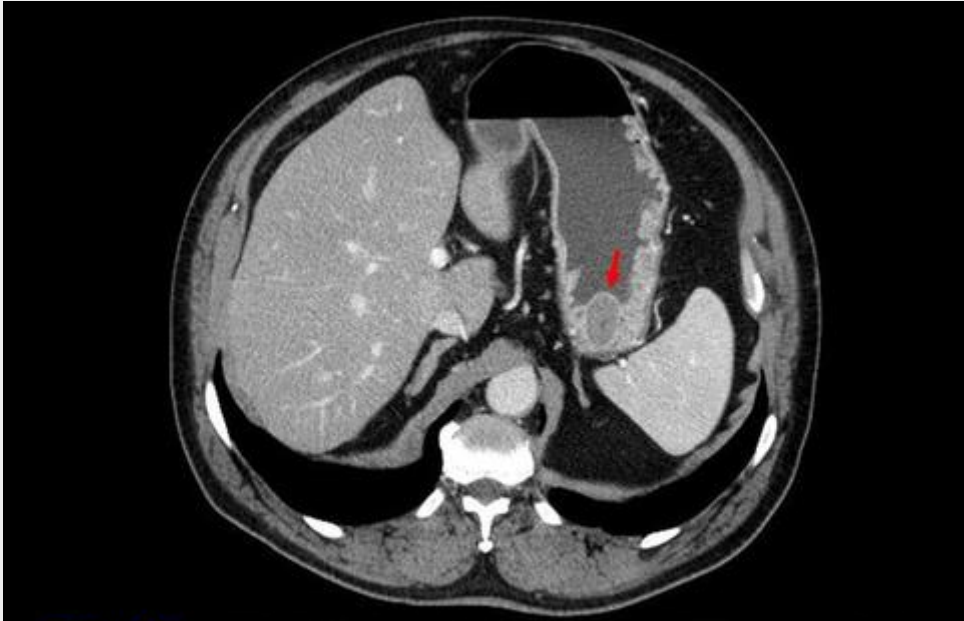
GIST. CT after IV contrast shows minimal enhancement. Note the overlying hiperattenuating, normal thickness mucosal layer, agreeing with it's submucosal origin (→).
